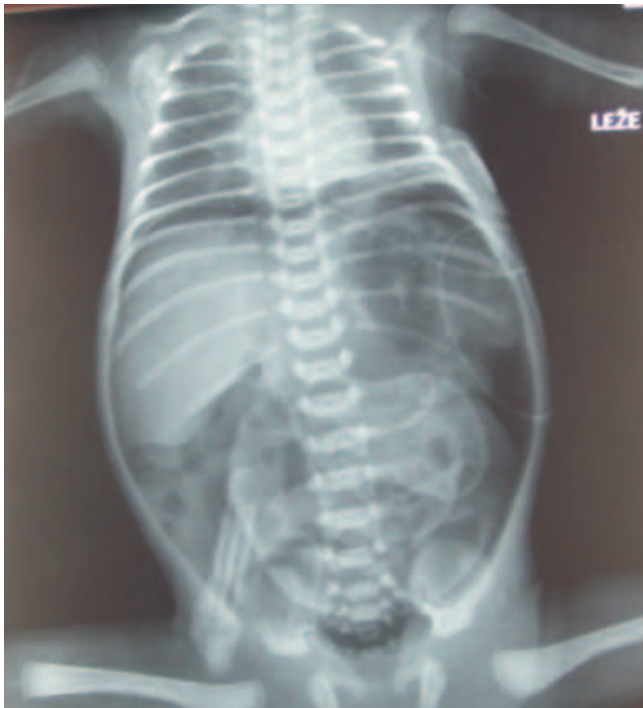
A plain abdominal X-ray showing free air in the peritoneal cavity.
